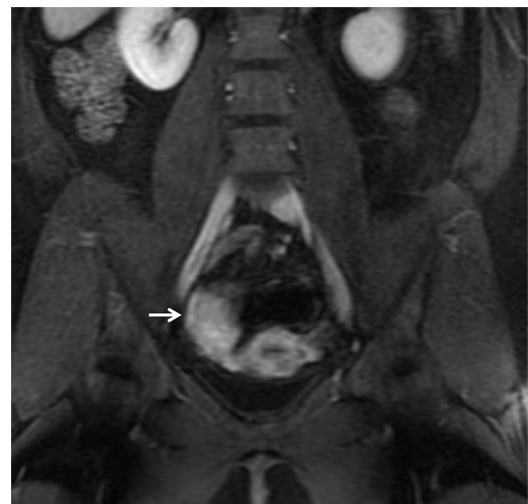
Coronal post-contrast T₁WI MRI of the pelvis showed an enhancing mass in the right adnexa (arrow), not seen separate from the right ovary. The uterus was normal. T₁WI, T₁-weighted image.
